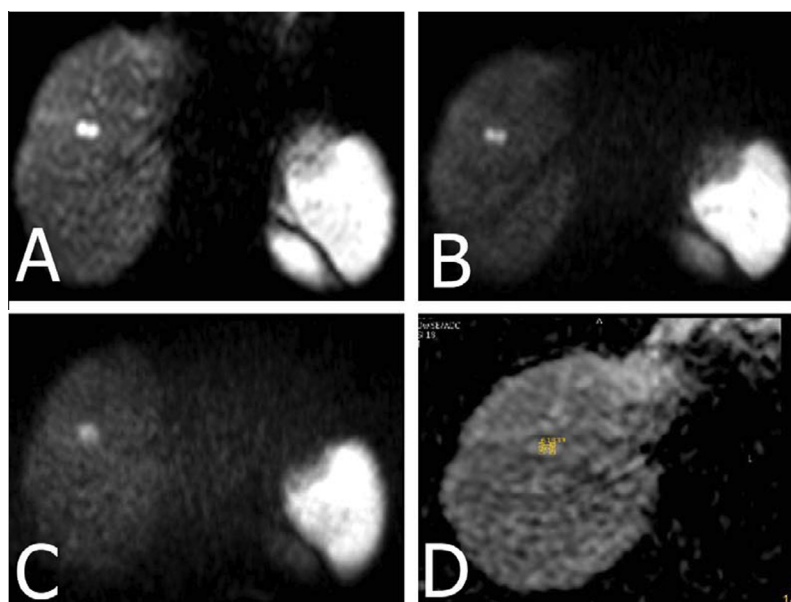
Diffusion weighted MR images of female patient, aged 35 years with small focal hemangioma, DWI at b 0 (A), b 500 (B), b 1000 (C). ADC map at b 1000 (D) shows relative high SI with high mean ADC value = $1.7 \times 10^{-3} \text{ mm}^2/\text{s}$.
